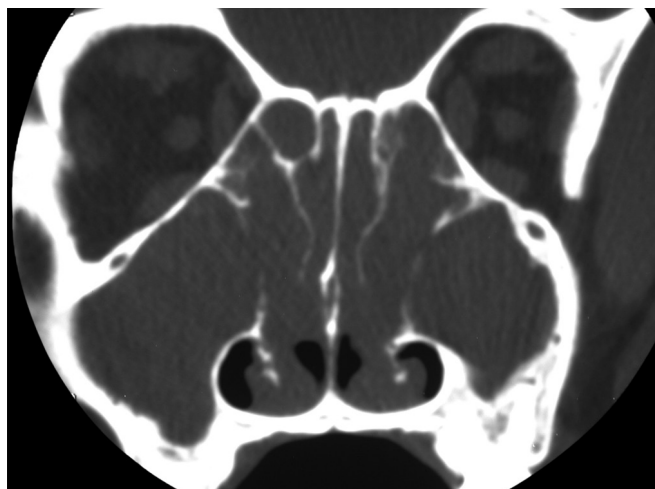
Coronal CT scan demonstrating panopacification of the maxillary and ethmoid sinuses.
